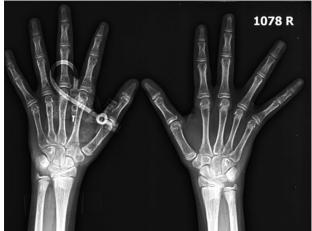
X-ray hands showing subperiosteal erosions and cystic lesions
